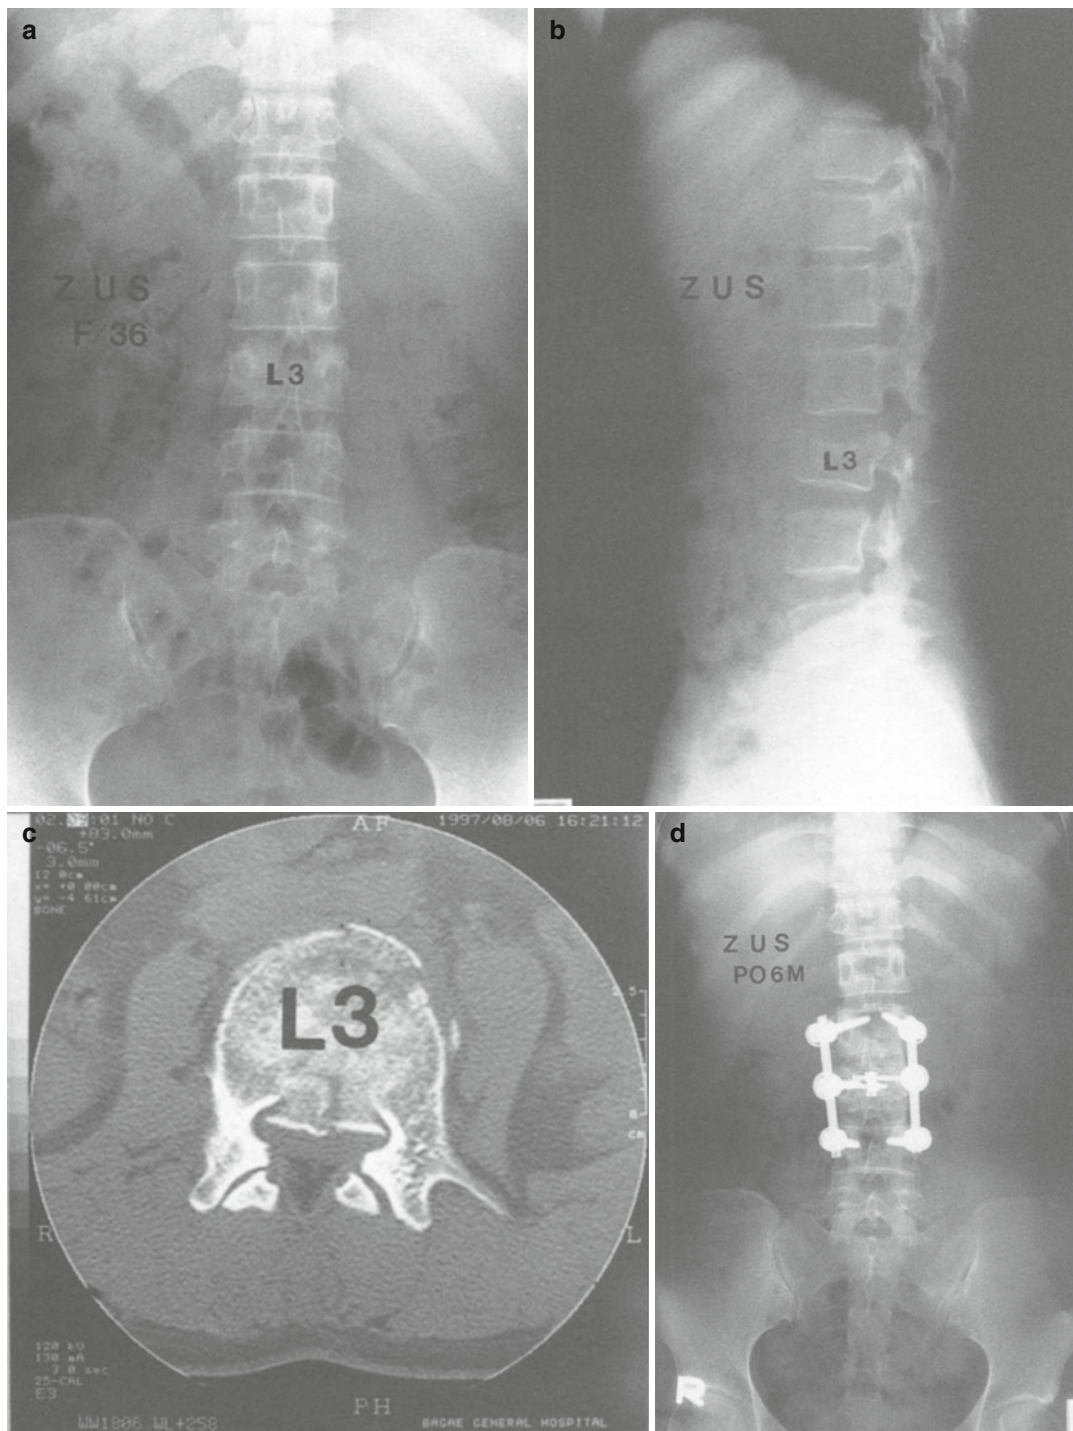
(a, b) A 36-year-old female with L3 unstable burst fracture. (c) Preoperative CT shows 50 % canal encroachment with severe destruction of vertebral body.
